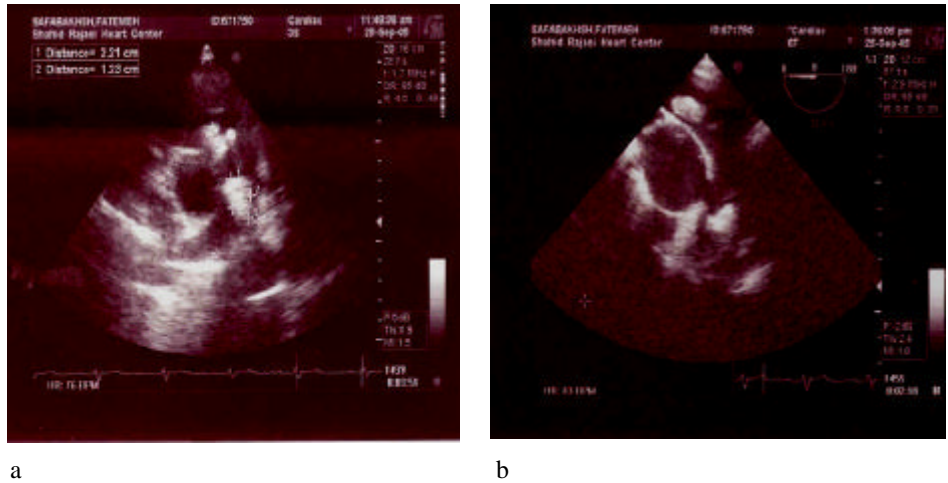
Transthoracic (a) and transesophageal (b) views showed large vegetations in pulmonary valve and in right pulmonary artery
